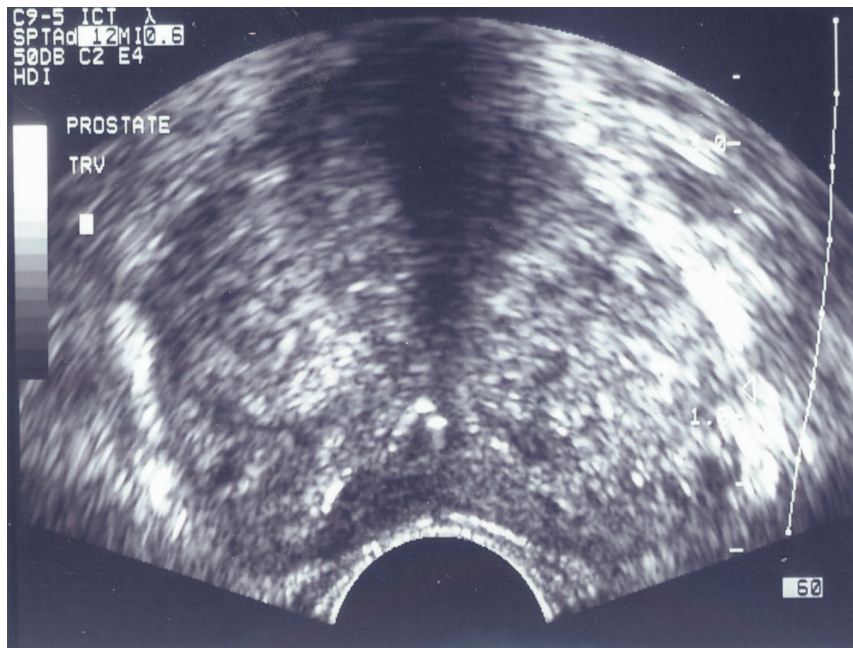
Shows an ultrasound scan performed for estimation of the prostate gland volume, which can be measured by the physicist or technologist easily
